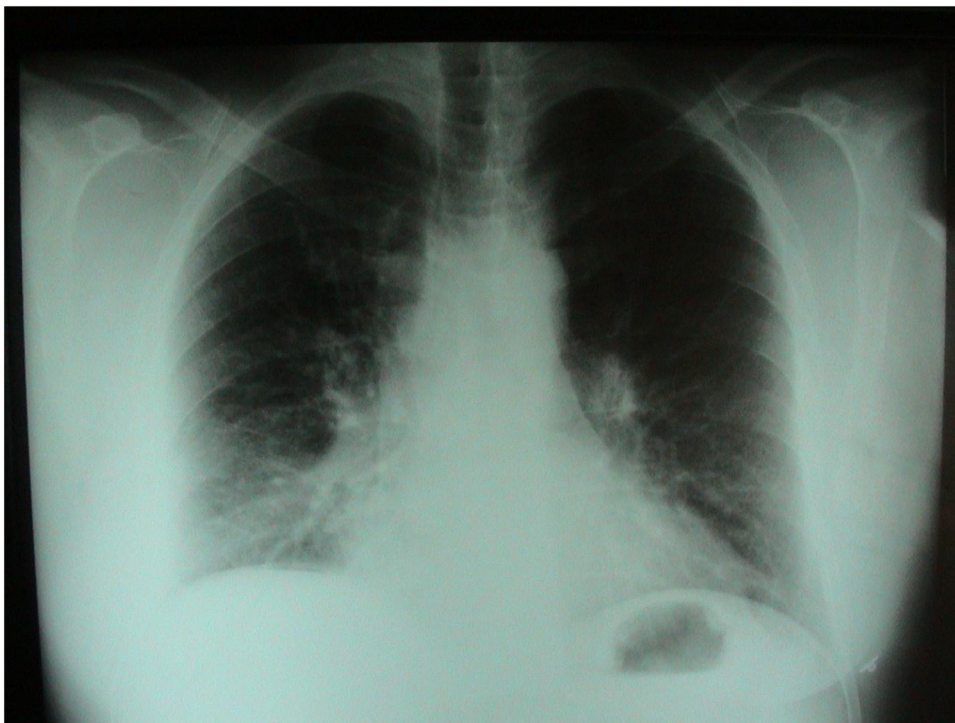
Chest X-ray (AP): Right lung base infiltrates.
